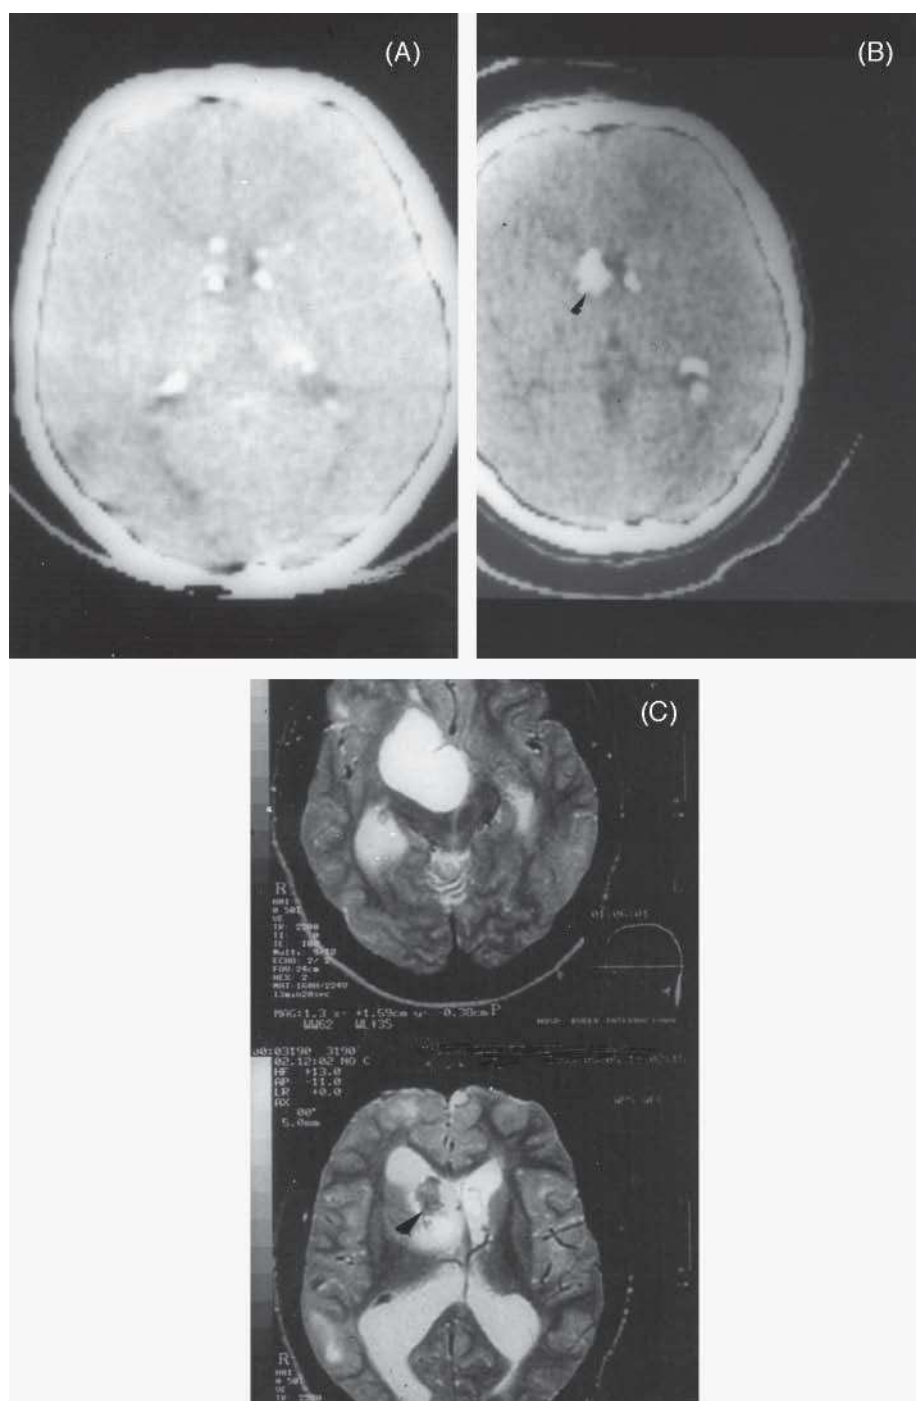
Case 3. A: computed tomography (CT) scan study at age 11. It shows small calcifications in areas of the anterior section in both lateral ventricles, perhaps somewhat larger and more numerous on the right. B: CT scan study at age 15. It shows a larger size of the hyperdensity on the right side (arrowhead) and also the beginning of a discrete left ventricular dilation. C: two axial sections of magnetic resonance imaging at age 24. Images of cystic tumour at two levels, with a small solid portion (arrowhead) and dilation of both lateral ventricles, the right side more so.
